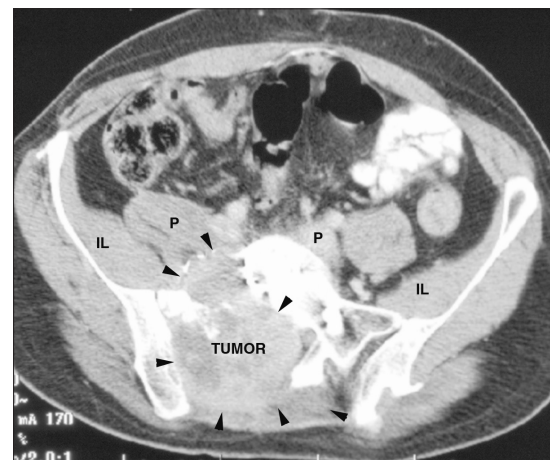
Pelvic CT scan reveals a large tumor mass (black arrowheads) with erosion and destruction of the right sacrum. Retroperitoneal extension of tumor has infiltrated into the right iliacus (IL) and psoas (P) muscles
